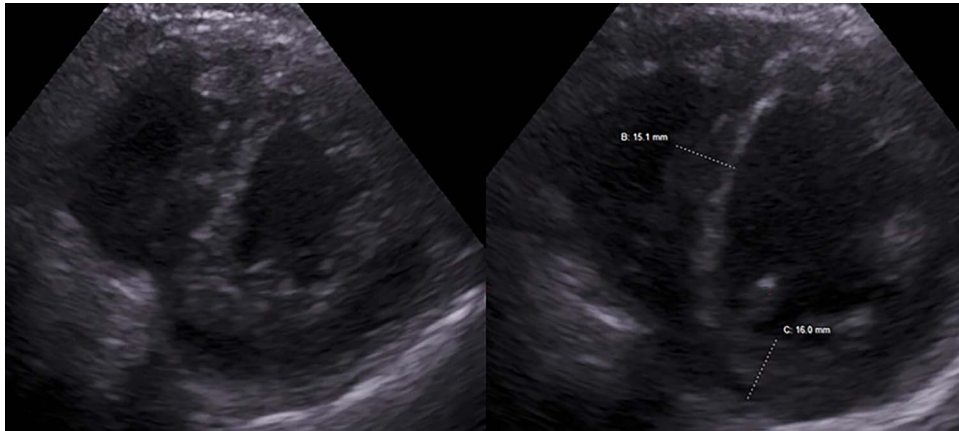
Parasternal short-axis view of the heart obtained with a 5–1 MHz phased-array transducer at the level of the papillary muscles shows a thickened interventricular septal wall measuring 15.1 mm as well as a thickened left ventricular posterior wall measuring approximately 16 mm.
